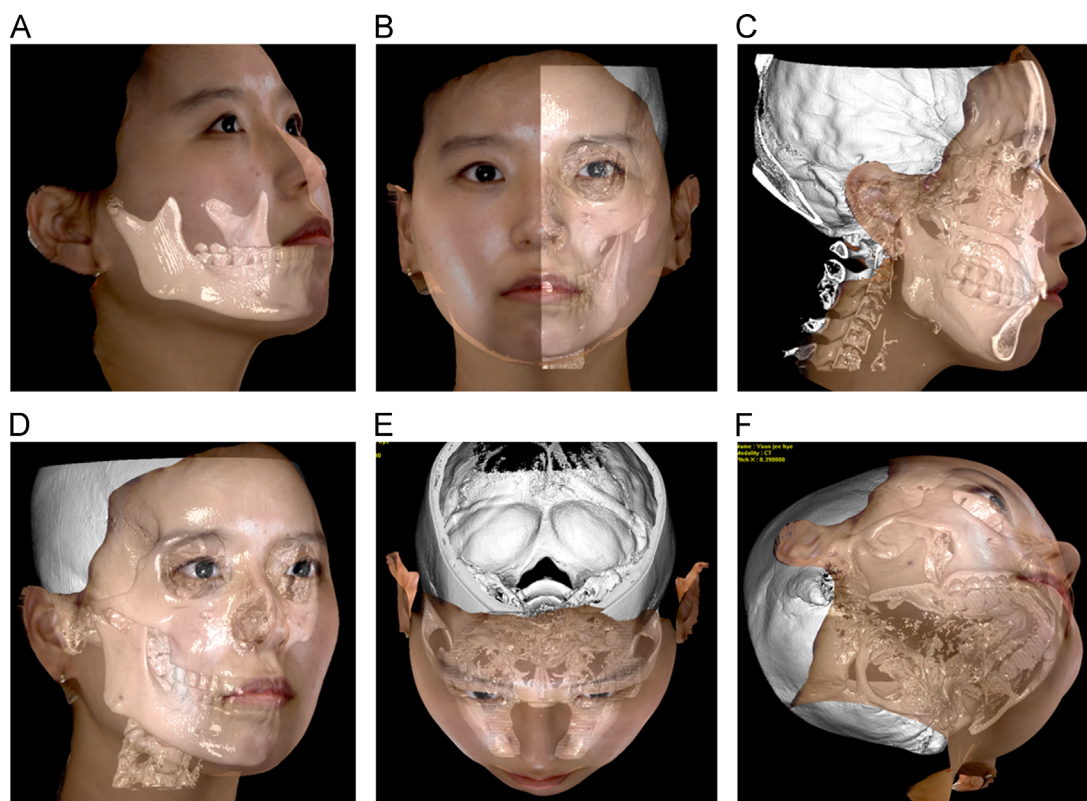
3D photograph superimposition over CBCT scan with Morpheus3D CT software (Morpheus). The 3D photographs superimposed over (A) volume rendered mandible, (B) mid-sagittal section of the CBCT (frontal view), (C) mid-sagittal section of the CBCT (lateral view), (D) full CBCT (¾ view), (E) superior view with anterior coronal section of the CBCT, and (F) inferior ¾ view with sectioned out mandible.
